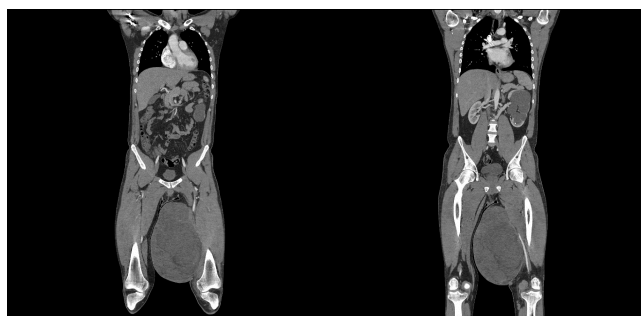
Coronal CT-angiography scans: no signs of femoral vessels infiltration.
